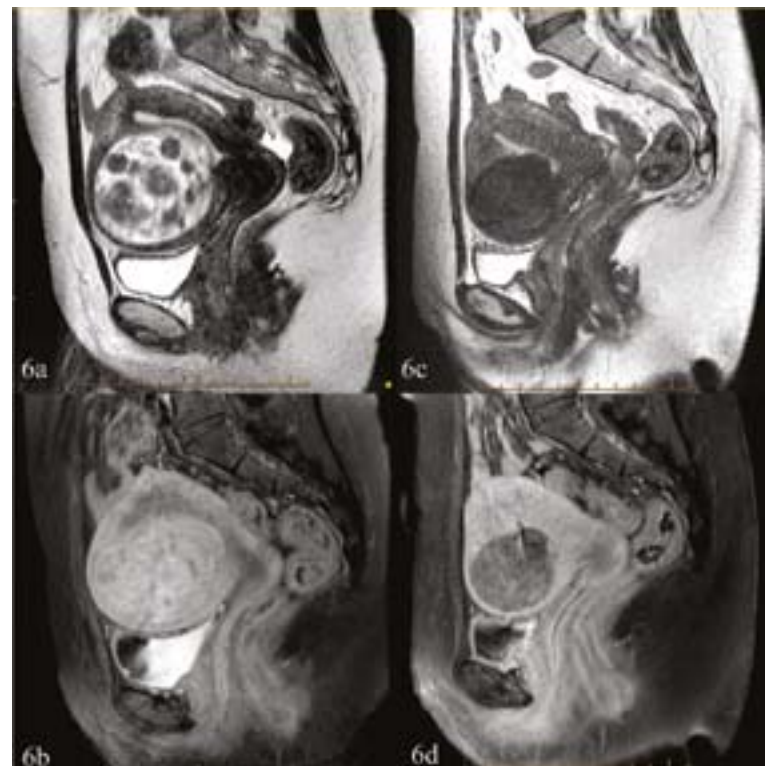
Pre and Post UFE MRI appearance of fibroid. A: T2W MRI shows a large transmurular fibroid slightly distorting the uterine cavity. The fibroid is predominantly high signal suggesting high cellularity. B: Fat saturated contrast enhanced MRI showing high vascularity. C: T2W MRI 6 months post UFE showing reduction in size and loss of signal. D: Fat saturated contrast enhanced MRI showing lack of vascularity, confirming fibroid infarction.
